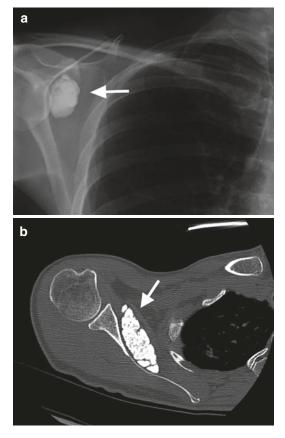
A 43-year-old female with incidental soft tissue calcified mass over the right scapula (a) on CXR and (b) CT. Imaging in keeping with an intracapsular chondroma within the subscapularis recess
